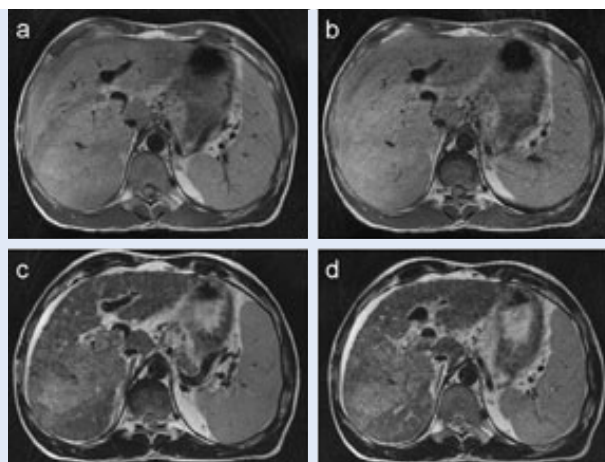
Examples of T2-weighted liver images: Breath-hold sequence without iPAT (a) and with iPAT (b), respiratory triggering without iPAT (c) and with iPAT (d). Respiratory triggering shows less motion artifacts and better delineation of the diffuse HCC due to better T2 contrast.
